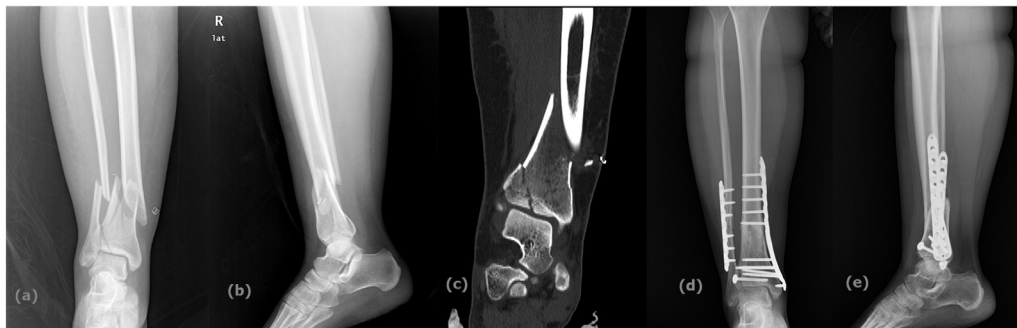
A 40-year-old female AO-OTA 43 C2 (a) preoperative X-ray, (b) preoperative computed tomography, (c) early postoperative X-ray, (d, e) postoperative X-ray at 28th month.
